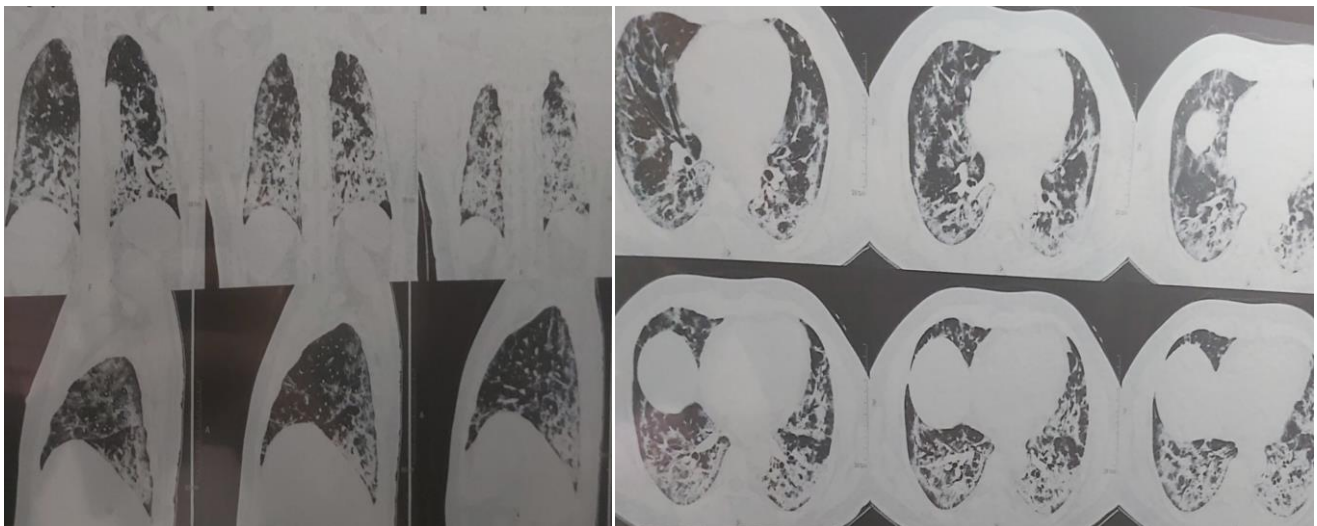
Figure IA and IB): CT-Scan of Chest Showing Extensive Bilateral Pneumonia Involving Both Lungs (Case 1)
